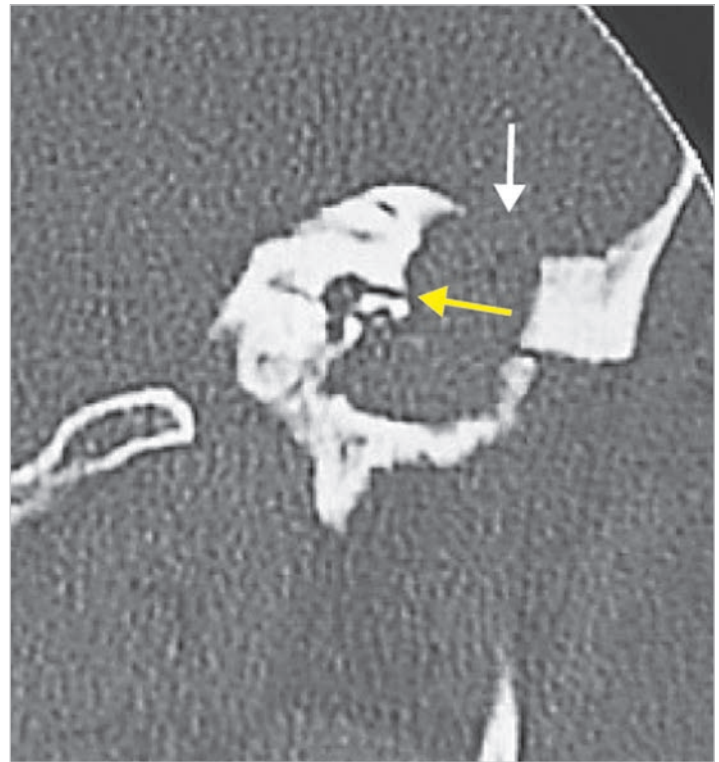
CT scan of the previous case. A huge cholesteatoma causing a fistula of the lateral semicircular canal (yellow arrow) and erosion of the tegmen can be seen (white arrow).
